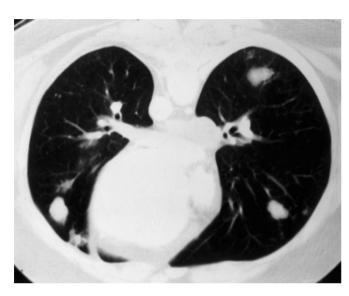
CT scan showing bilateral intraparenchymal pulmonary tumour nodules
